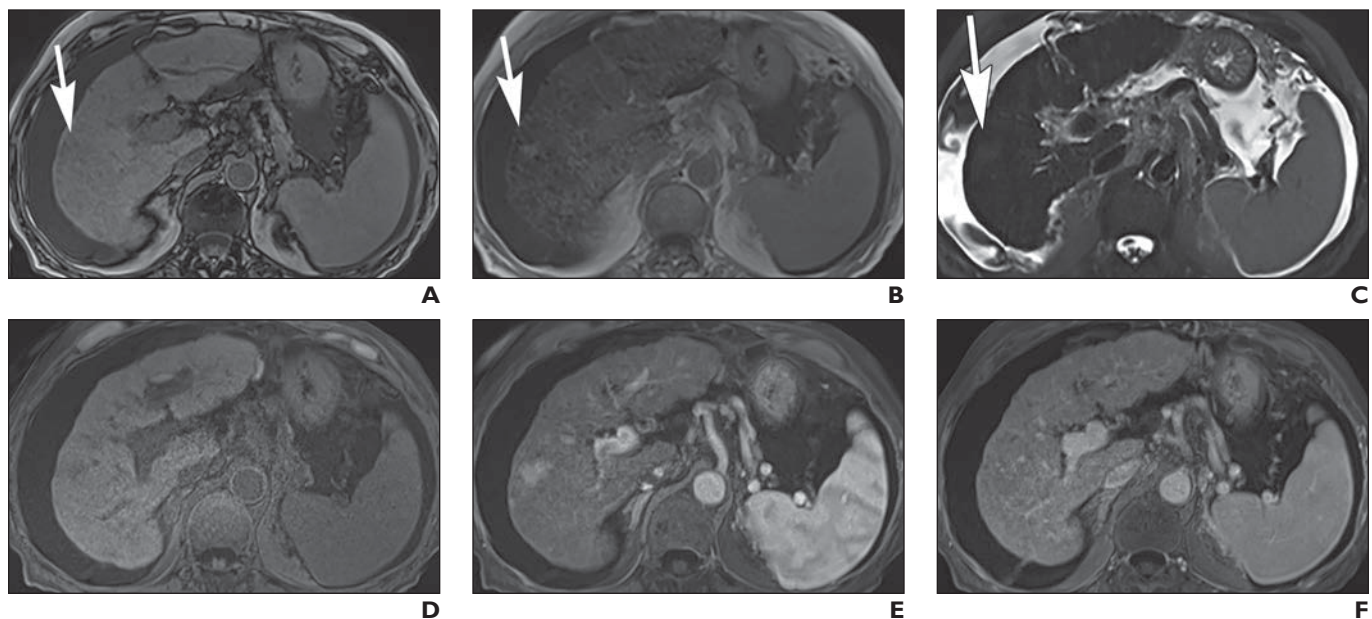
77-year-old woman with hepatitis C cirrhosis with iron-sparing in region of liver mass. Nodular and diffuse areas of loss of signal intensity are present throughout cirrhotic liver on in-phase T1-weighted MR images with longer TE compared with corresponding out-of-phase images, consistent with susceptibility artifact induced by iron deposition. Small (1.7-cm) area of iron sparing (arrow, A–C) is evident in right hepatic lobe with mildly increased signal intensity on arterial phase T2-weighted image. Assignment was LI-RADS category 3.
